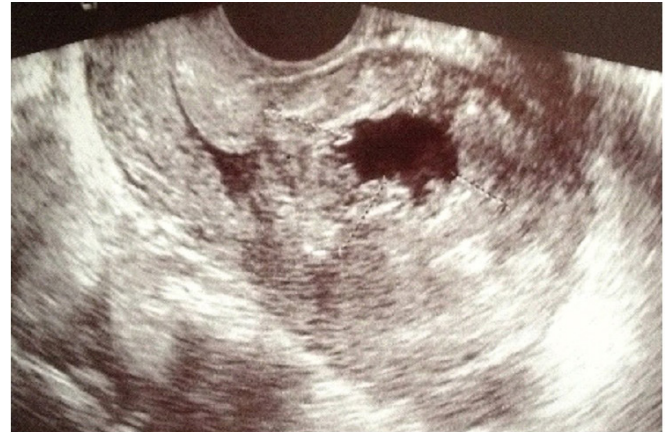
Transvaginal ultrasonography 1 week after curettage. Persistent ectopic gestational sac was still present in the lower part of the anterior uterine wall at the site of the cesarean section scar. Irregularity of the inner wall of the ectopic gestational sac was detected.
